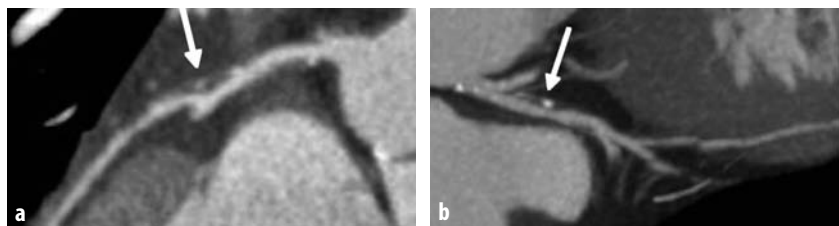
a-d. Plaque dissection (*arrow*) of the left anterior descending coronary artery. a Axial image shows the intimal flap; the central component of the plaque is filled with contrast agent (b, c). The patient suffered acute clinical symptoms a few hours before CT. d Bi-dimensional reconstructed image also shows the intimal flap. There is also a mild reduction in the caliber of the vessel in the proximal segment and a second fibrolipidic plaque (*arrows*)
